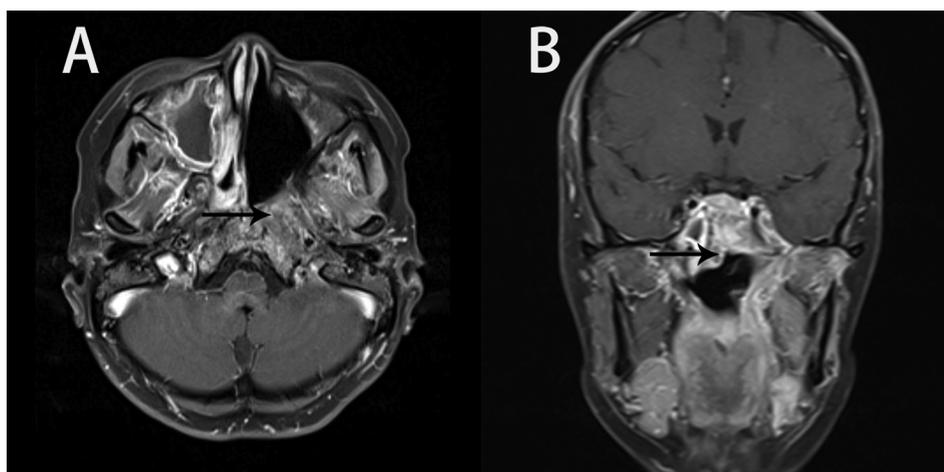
9.30 Follow-up contrast-enhanced MRI 14 months post radiotherapy: therapy-related changes: pterygoid fossa, pterygoid muscle and sphenoid sinus (A) and oval foramen, cavernous sinus (B).
